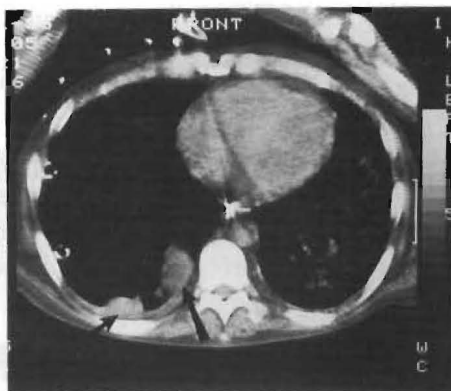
CT scan of chest further demonstrating and delineating these peculiar, persistent lesions seen on chest x-ray.
